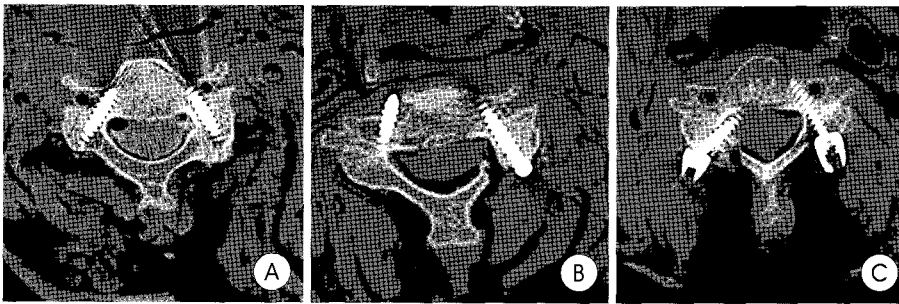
Axial computed tomography scans. A : Both cervical pedicle screws are inserted properly within the cervical pedicle by the blind technique. B : The right cervical pedicle screw perforating the lateral pedicle toward the vertebral artery by the blind technique, and the left cervical pedicle screw perforating the lateral pedicle toward the vertebral artery by the laminotomy technique. C : The right cervical pedicle screw perforating the medial pedicle toward the spinal cord by laminotomy technique and the left cervical pedicle screw inserted properly within the cervical pedicle by the funnel technique.
